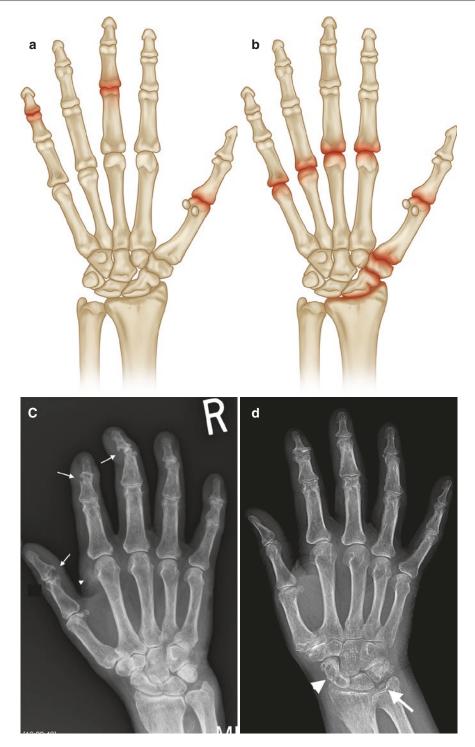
Common sites of involvement with (a) gout and (b) CPPD arthropathy. (c) PA radiograph of the right hand in a patient with a 15-year history of gout and chronic renal failure with marginal erosions (*arrows*), some with overhanging edges (first IPJ), and gouty tophus (*arrowhead*). Note absence of periarticular osteopenia. There was asymmetrical left hand involvement (not shown).
